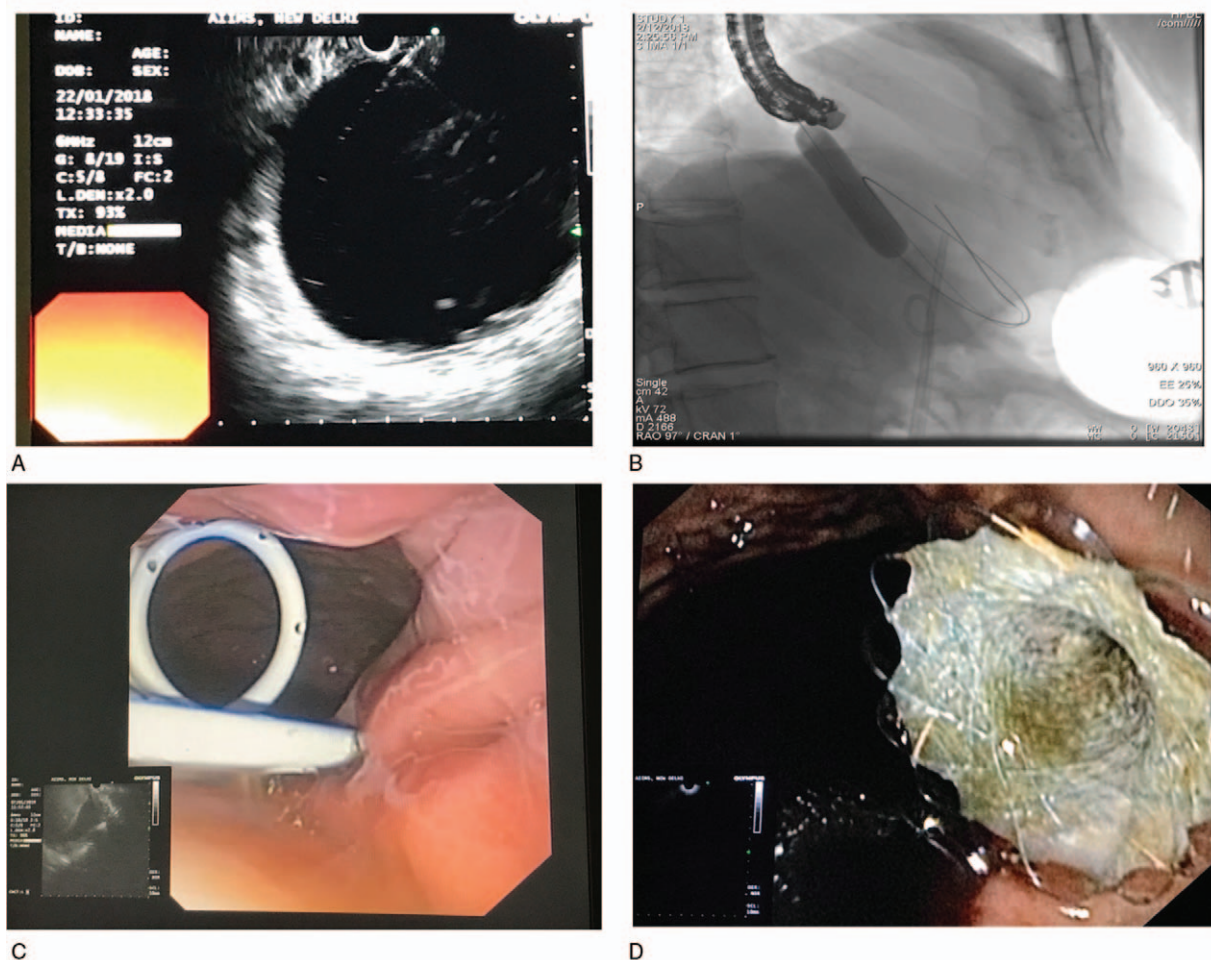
Endoscopic transmural drainage: (A) puncture of the pseudocyst/WON under EUS guidance and placement of guidewire, (B) balloon dilatation of the tract, (C) placement of 2 plastic stents, (D) Lumen opposing metal stent. EUS = endoscopic ultrasound, WON = walled-off necrosis.
